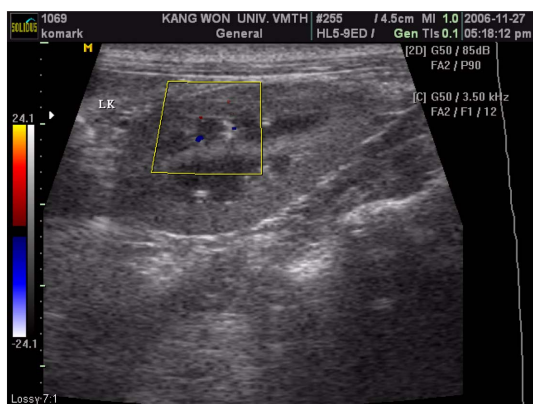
Ultrasonographic findings in the kidney. Kidney was normal in shape and size with poor corticomedullary definition and a hyperechoic cortex. Blood flow in renal arteries and veins were remarkably reduced, suggesting chronic renal parenchymal disease.
